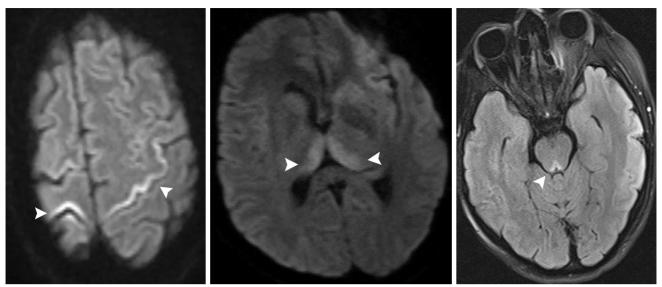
Diffusion-weighted brain magnetic resonance imaging shows diffusion restriction in the bilateral precentral gyri, dorsomedial thalami, and mammillary bodies (arrowheads).
